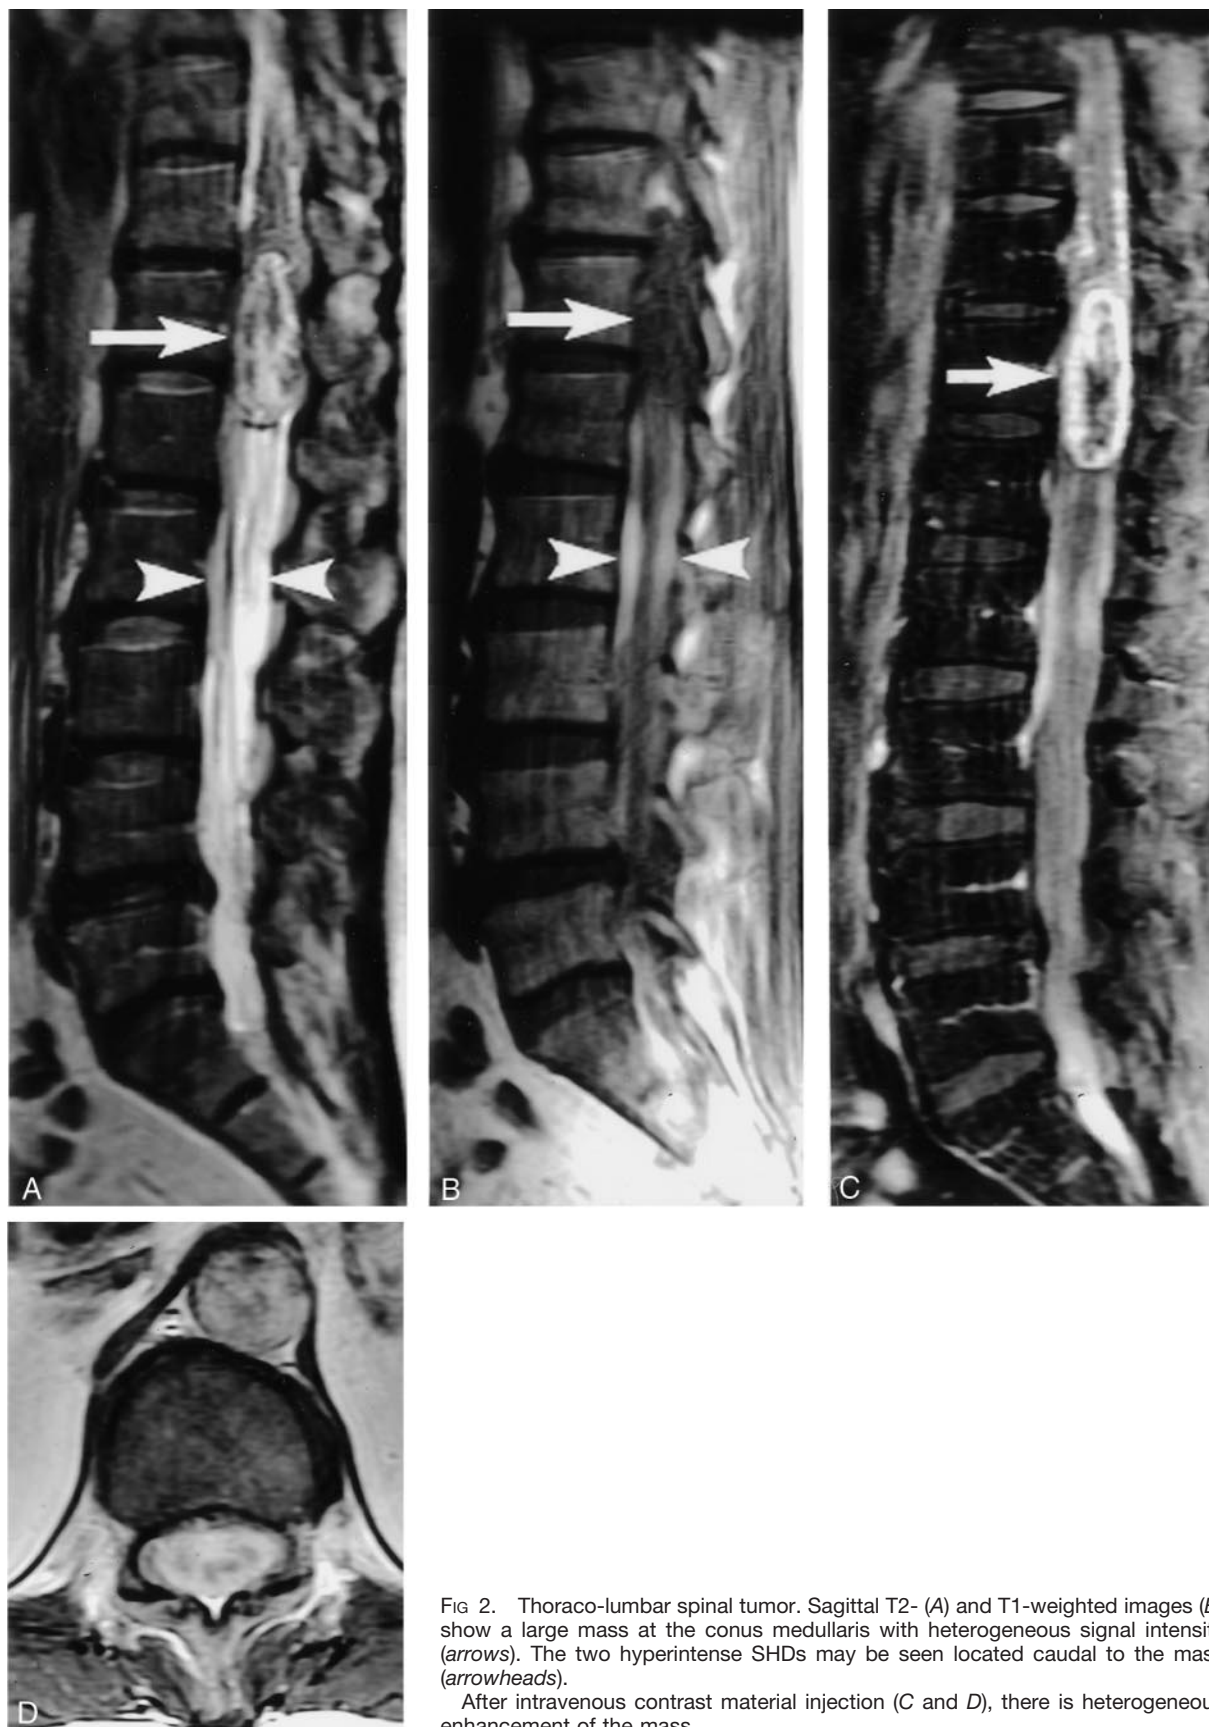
Thoraco-lumbar spinal tumor. Sagittal T2- (A) and T1-weighted images (B) show a large mass at the conus medullaris with heterogeneous signal intensity (arrows). The two hyperintense SHDs may be seen located caudal to the mass (arrowheads).
